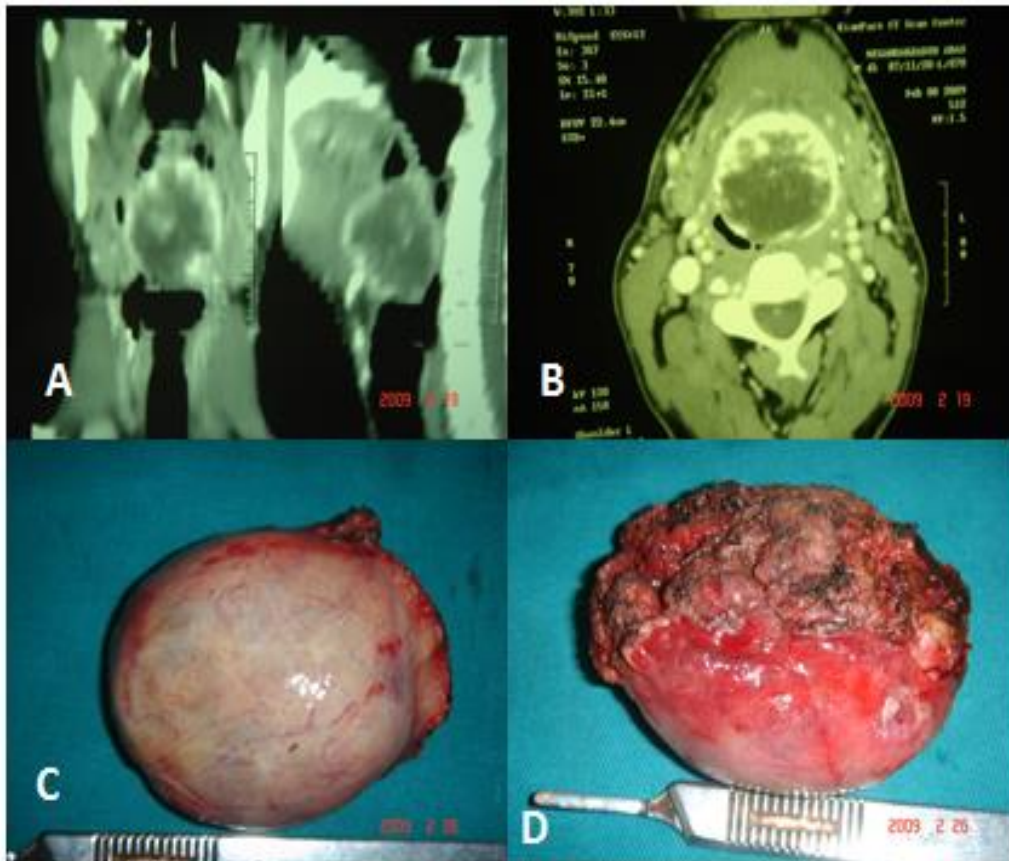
A 45 years old male had suffered from a lump-in-the-throat sensation, dysphagia, body weight loss, A, B: CT scan of the lingual thyroid, C, D: Excised mass
